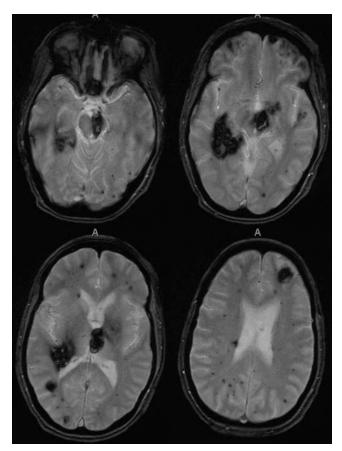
Axial gradient-recalled echo MR images obtained in a 52year-old woman with familial CMs. This patient had multiple foci of gradient blooming artifact.
